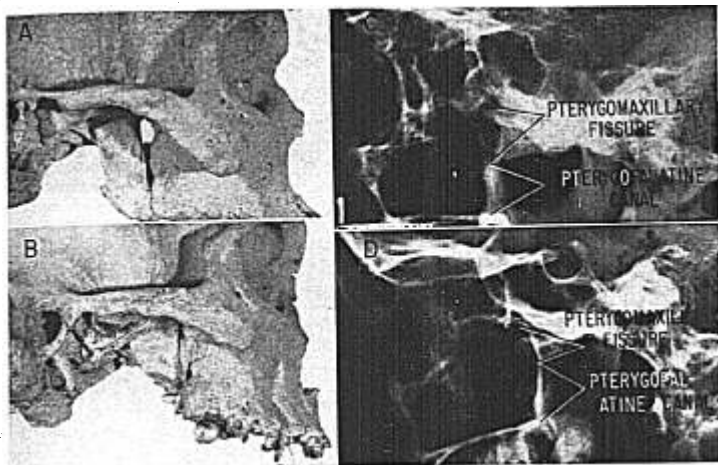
Photographs of two skulls. One (A) with a long and wide pterygomaxillary fissure and the other (B) with a narrow and short pterygomaxillary fissure. The skulls are tilted to show the whole length of the fissure. Radiograph (C) of skull showing long and wide pterygomaxillary fissure and radiograph (D) of skull showing a narrow and short pterygomaxillary fissure.
